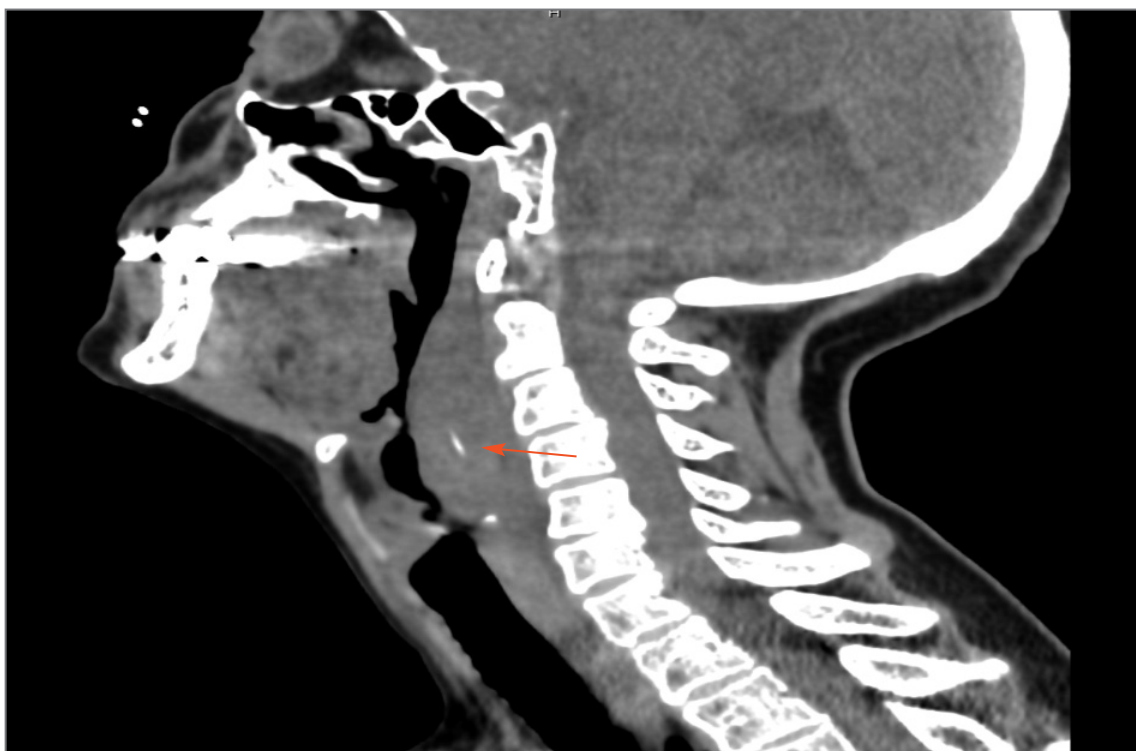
CT scan of sagittal section: prevertebral soft tissue swelling with a fish bone – arrow
